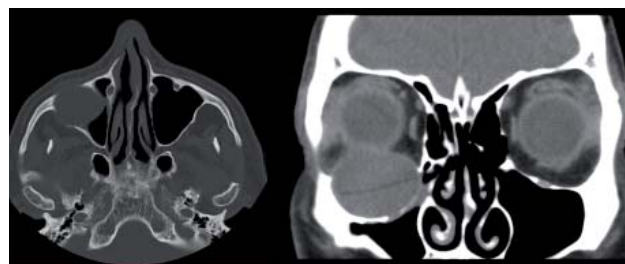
Transverse and coronal slices of CT orbit taken in 2012
